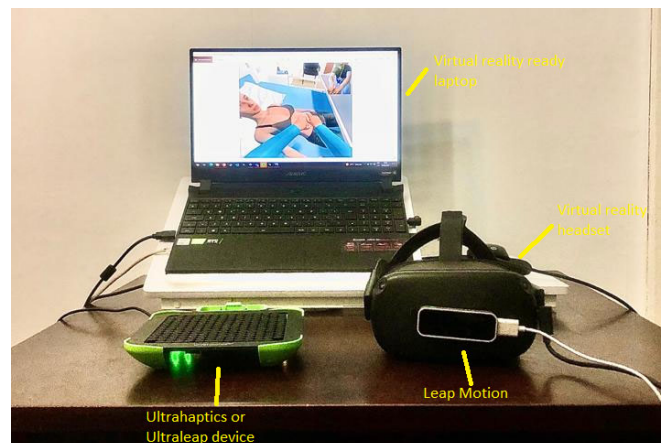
We require a virtual reality headset, a Leap Motion, and a “VR ready Laptop”. It is possible to connect several ultrasound-based haptic devices and a monitor.
